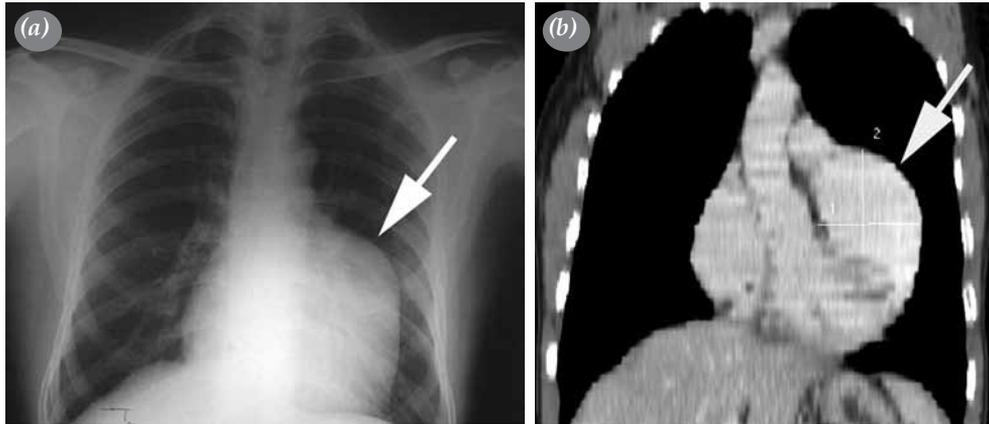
(a) Chest X-ray showing prominence at the left heart border (arrow). (b) Contrast enhanced computed tomography showing giant aneurysm of left atrial appendage (arrow).
